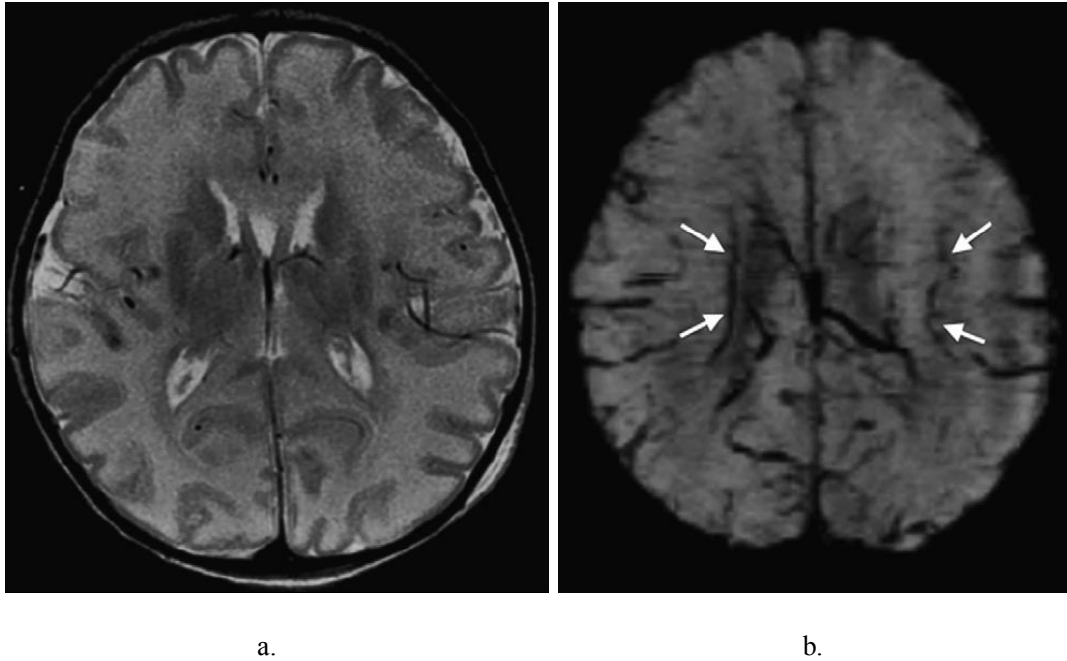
An infant with HIE scanned at five days. a) T2-weighted image; b) SWI image [66]
